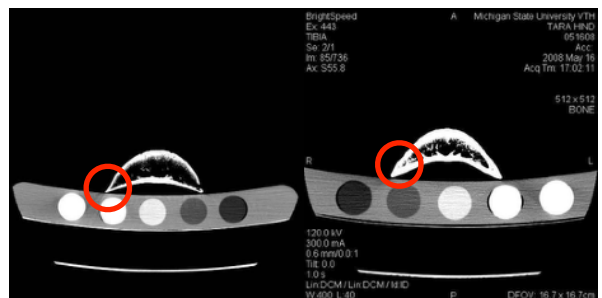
CT scans bones of same width. Density of bone will vary depending on how they were loaded. A peripherally loaded foot will be less dense, while a solarly loaded foot is dense and symmetrical.
